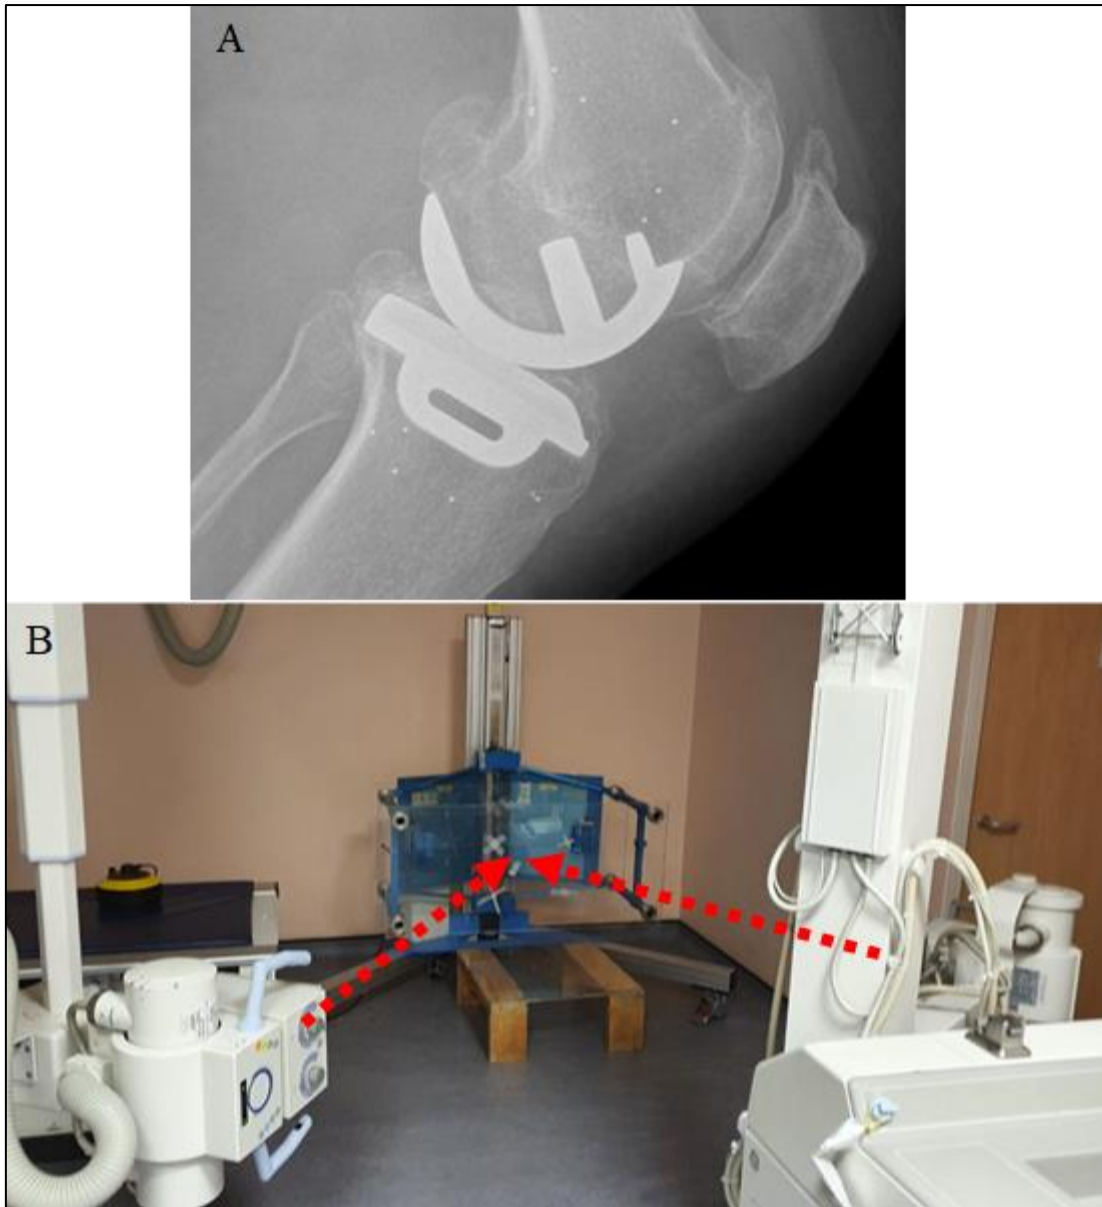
A Plain lateral radiograph of showing the seven femoral and six tibial tantalum marker malls, positioned proximal to the femoral component in the femur and distal to the tibial component in the tibia. B The set-up for capturing stereoradiographs for this study. Two X-ray tubes are positioned 1.5 metres from the calibration frame (blue) angled at 60 degrees to perpendicular. Both tubes were aligned to target the knee of the patient standing in the calibration frame, with the red arrows indicating the theoretical path of the X-rays to the target.
